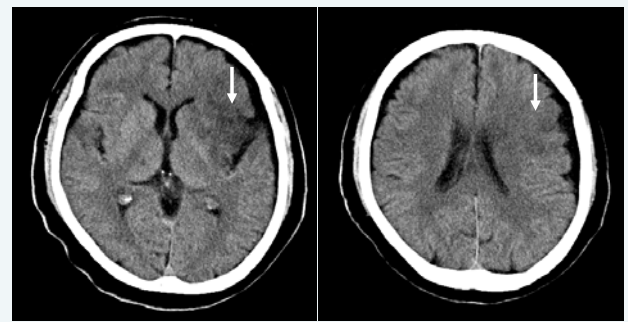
Head CT scan performed on the day after the procedure showing no hemorrhagic change and no enlargement of the ischemic area (arrow).
